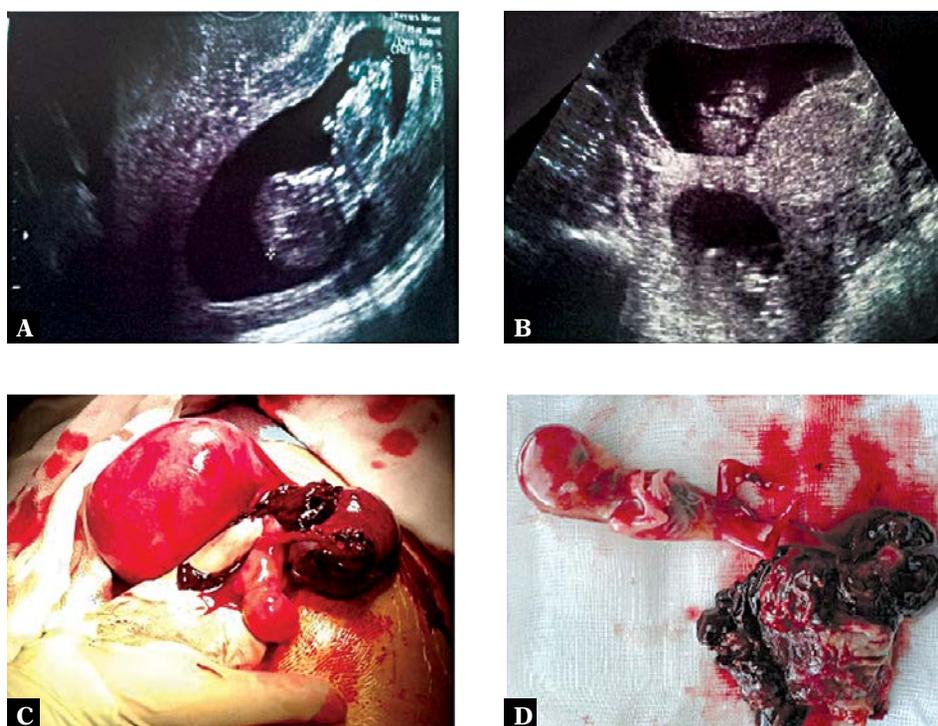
Heterotopic pregnancy in ultrasound and during surgery. A. Scan at 11 weeks of gestation measuring the intrauterine fetus (different hospital). B. Scan at 11 weeks of gestation showing a “pseudo twin pregnancy” (different hospital). C. Ruptured right fallopian tube with the ectopic pregnancy during the surgery. D. Ruptured right fallopian tube with the ectopic pregnancy – after salpingectomy
